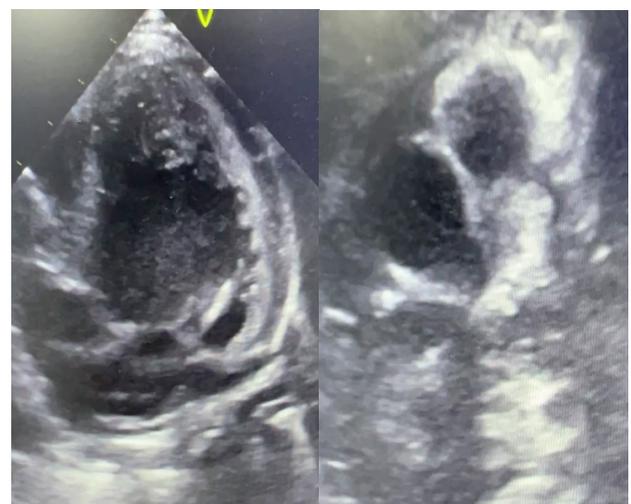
Transthoracic echocardiography demonstrating left ventricular dilatation, hyperechogenic mitral papillary muscle and anomalous origin of the left coronary artery arising from the pulmonary artery.
